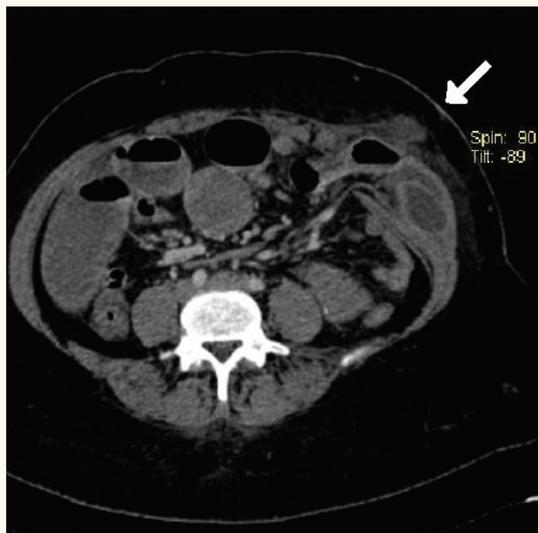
Computed tomography (CT) scan shows the dilated small bowel which is protruding into the muscular layer of the abdominal wall (arrow).
